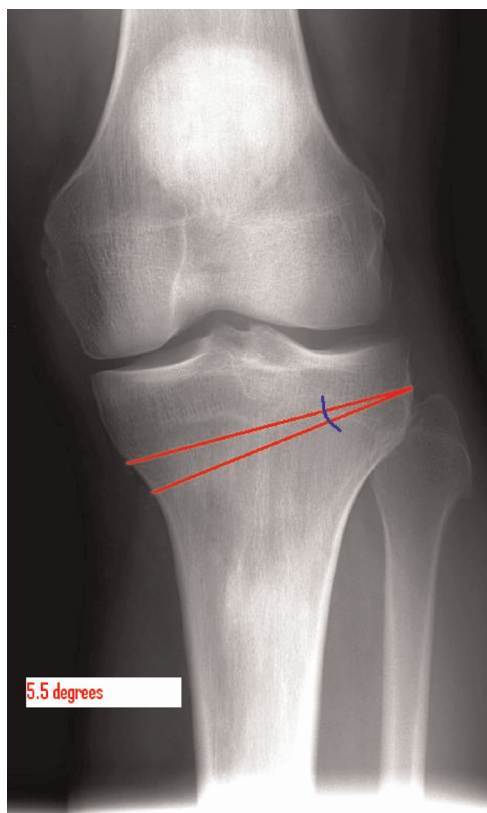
A detailed radiograph using the modified technique of Miniaci et al<sup>5</sup> for angular correction including plate determination.
